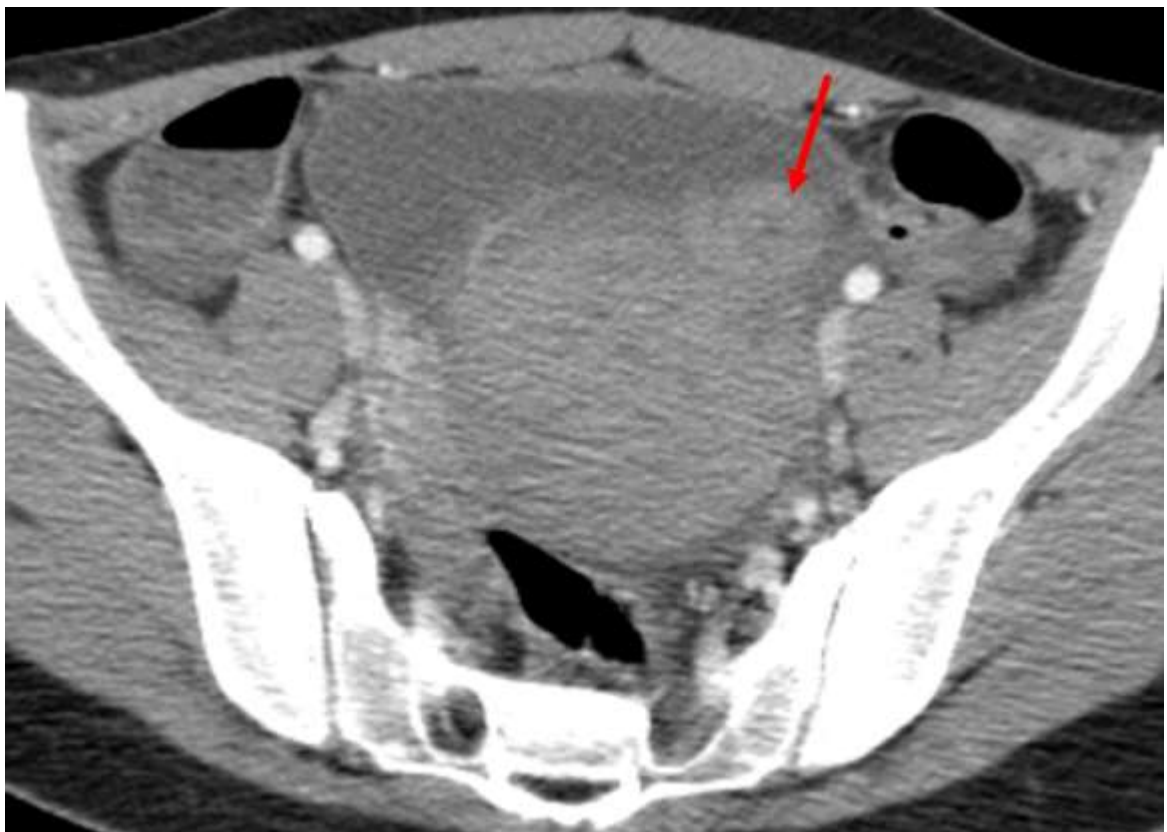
Pelvic CT injected in axial section showing a turn of the spire (red arrow).
